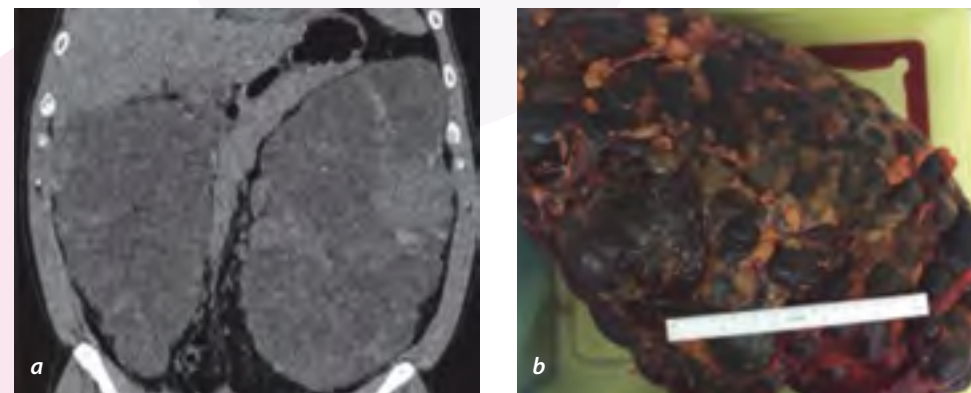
(a): massive polycystic kidneys on CT scan (more than 5 times the size of normal kidneys). (b): a polycystic kidney following surgical removal.
